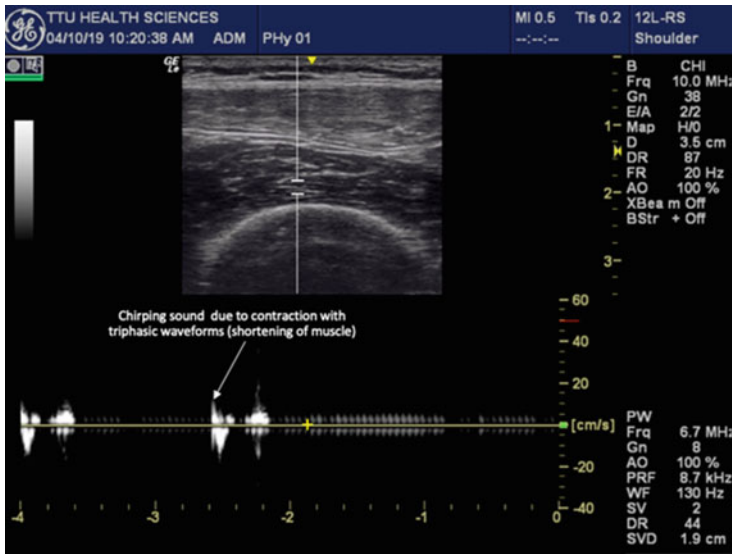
Doppler mode: insonating the vastus intermedius; a chirping sound with biphasic or triphasic waveform
